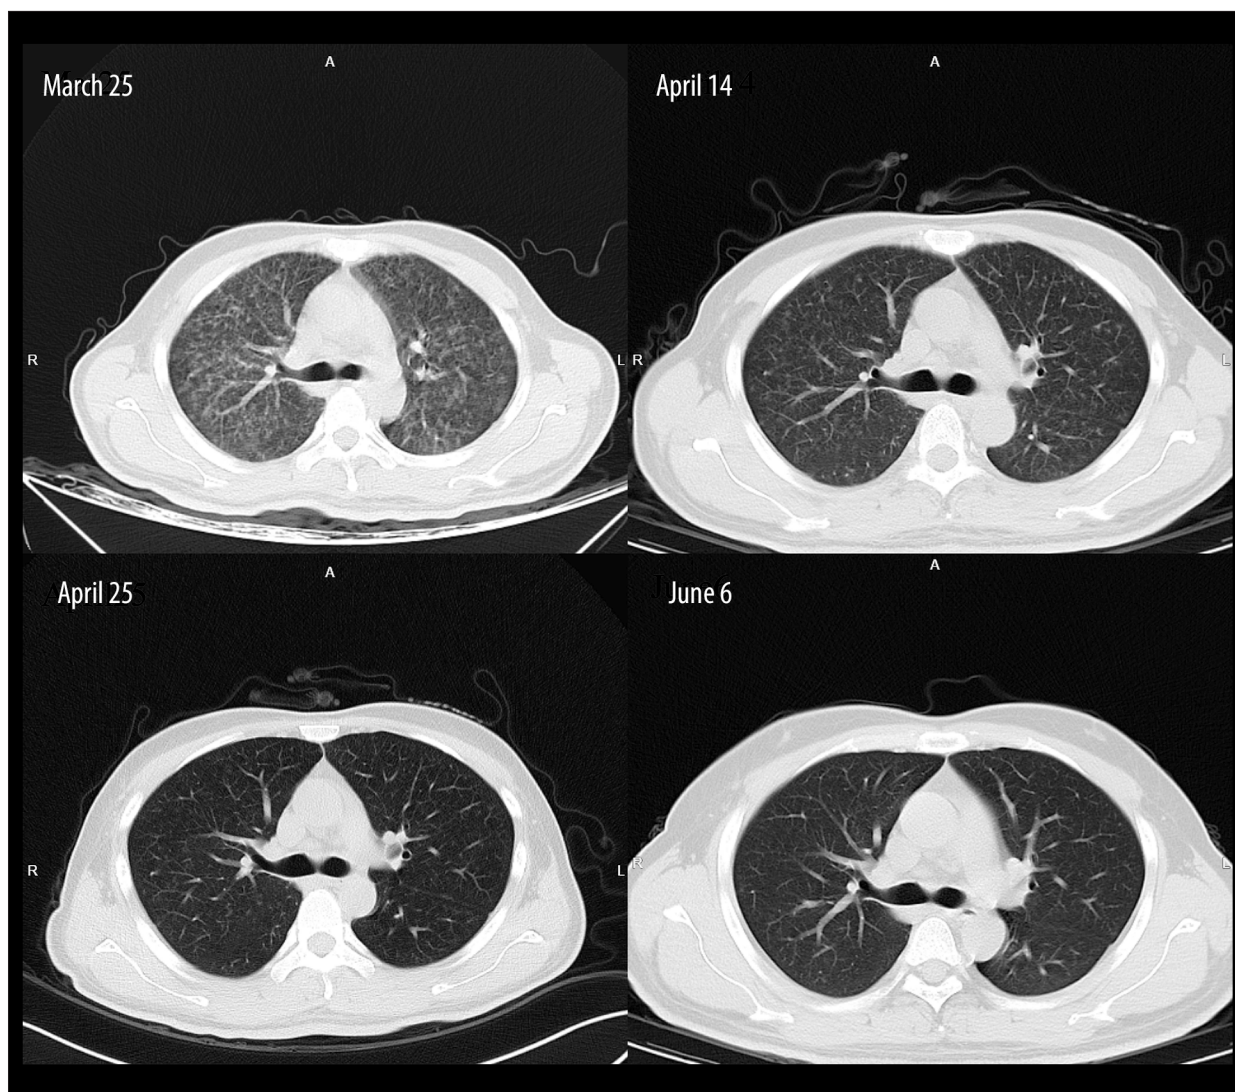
The signs of computed tomography imaging are miliary nodules, interstitial involvement, bilateral lung involvement, and involvement of multiple segments. The pulmonary shadows gradually absorb and dissipate as treatment progresses.
